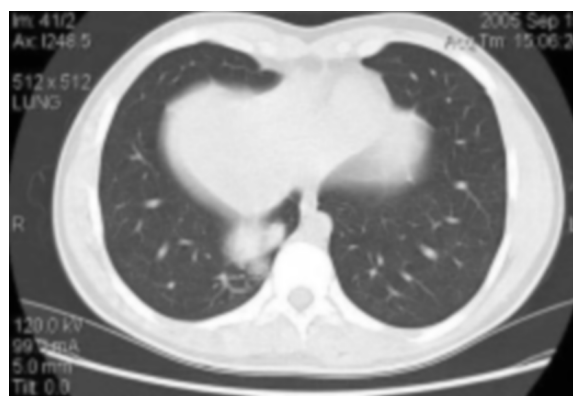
Axial CT image in lung settings shows the posterior right costophrenic poorly margined lesion.
